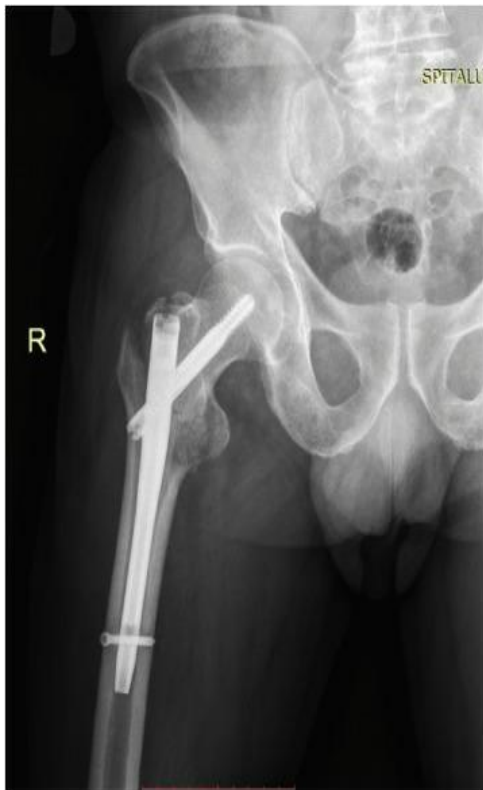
X-ray image of hip joint
